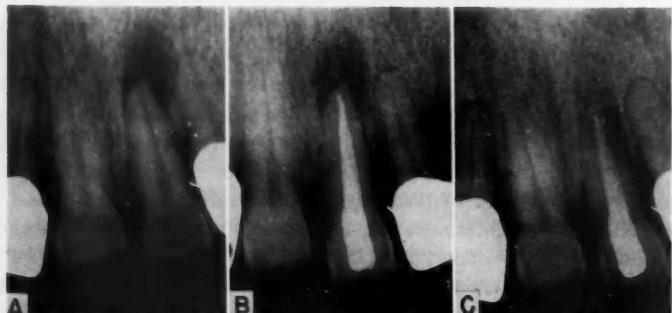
Upper central incisor with gangrenous pulp and rarefied periapical area. A sinus tract which drained to the labial was also present. A, Before treatment; B, immediately after treatment; C, 4 years after treatment.
